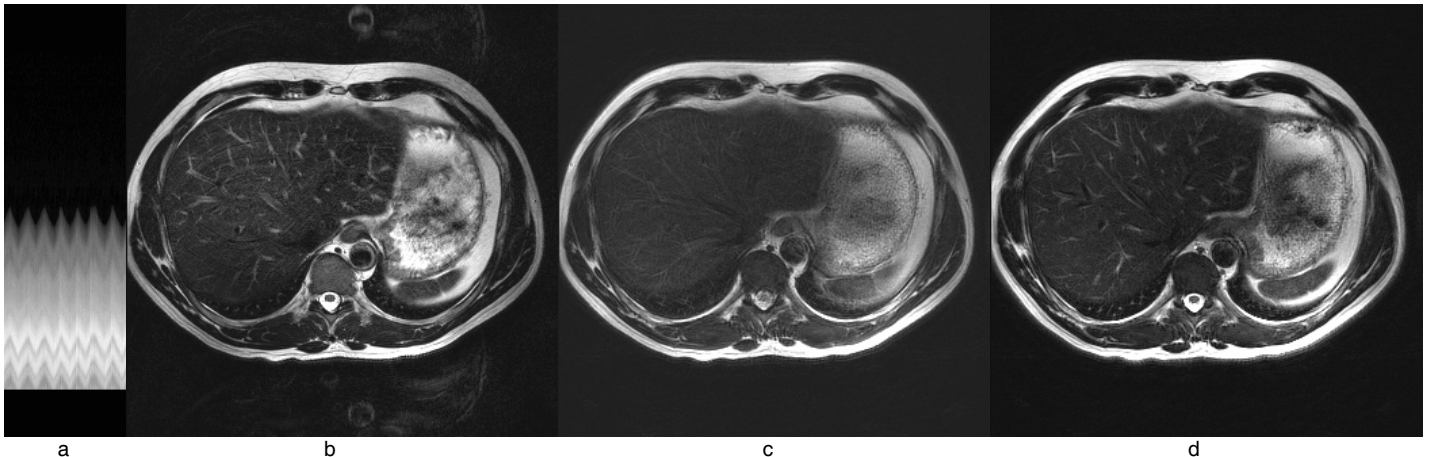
Images from 3T systems: (a) Diaphragm movement from PACE navigator. (b) T2-weighted TSE with Cartesian trajectory with PACE and iPAT shows in-plane motion artifacts. (c) T2-weighted TSE BLADE with iPAT but without PACE navigator shows blurriness caused by diaphragm through-plane motion. (d) T2-weighted TSE BLADE with iPAT and PACE shows no artifacts.
